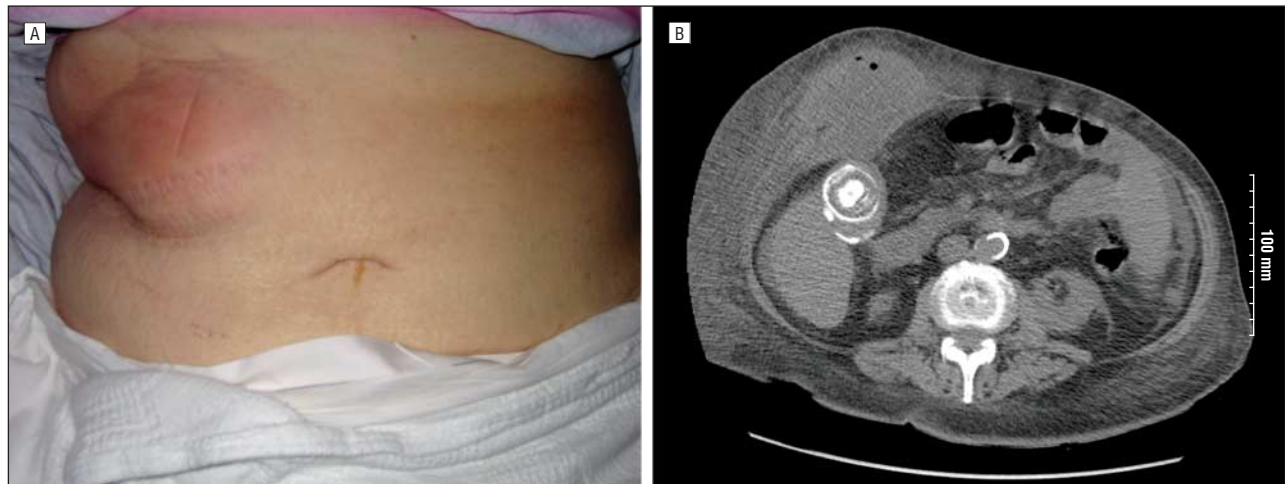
Physical examination and computed tomography findings. A, Right upper quadrant erythema, mild tenderness to palpation, and distention overlying a protruding, fluctuant mass in the right upper quadrant. B, Computed tomography image reveals a 5 \times 9-cm right anterior abdominal wall lesion.
